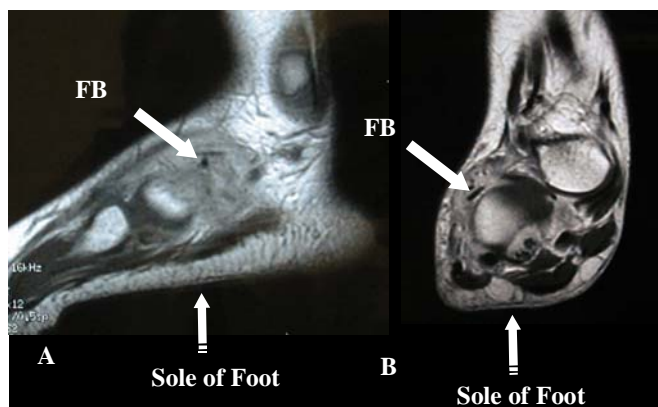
(A) Sagittal and (B) Coronal T 1 of the foot on a 10 year old female with a FB. Ultrasound over the puncture site on the sole of the foot was negative. (Puncture site not seen on these images). MR demonstrates a remarkably distant FB, easily seen on a subsequent ultrasound.
